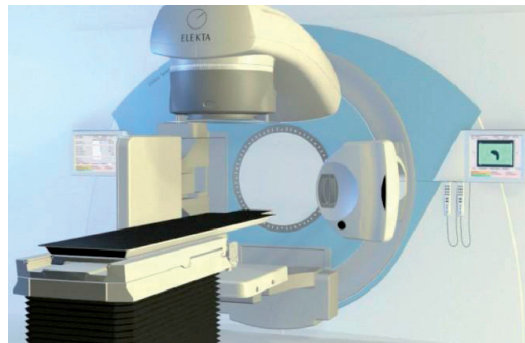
Modern linear accelerator with add-on imaging equipment. Radiation gantry and collimator (above the table), volume imaging system x-ray source (to the right) and detector (to the left), and electronic portal imaging detector (below the table, partly covered). From Elekta AB web pages.*
